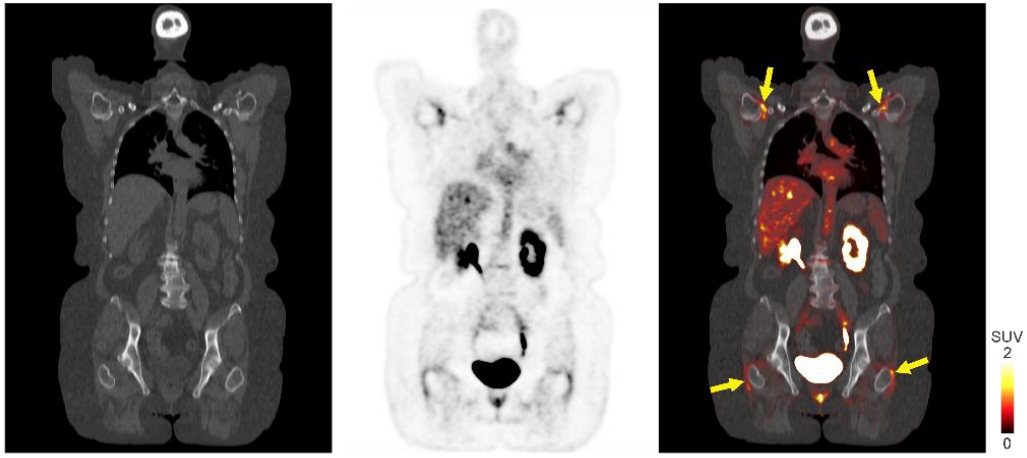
¹⁸F-FDS accumulation in fluids. Coronal CT (left), PET (middle), and overlaid PET/CT (right) from a patient with interstitial lung disease. ¹⁸F-FDS PET signal was observed in the synovial fluid (yellow arrows).
